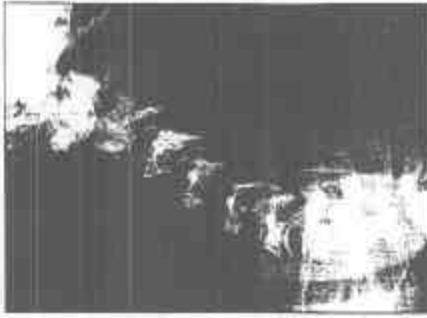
Lateral radiographic view of the cervical spine of an 8-week-old chondrodysplastic Great Pyrenees pup. Vertebral bodies were poorly developed and ossification was delayed compared with normal. The central border of vertebral bodies was plicated, and there were bony projections at the caudoventral aspect of the vertebral bodies. Ossification centers of the vertebral endplates were narrow.
